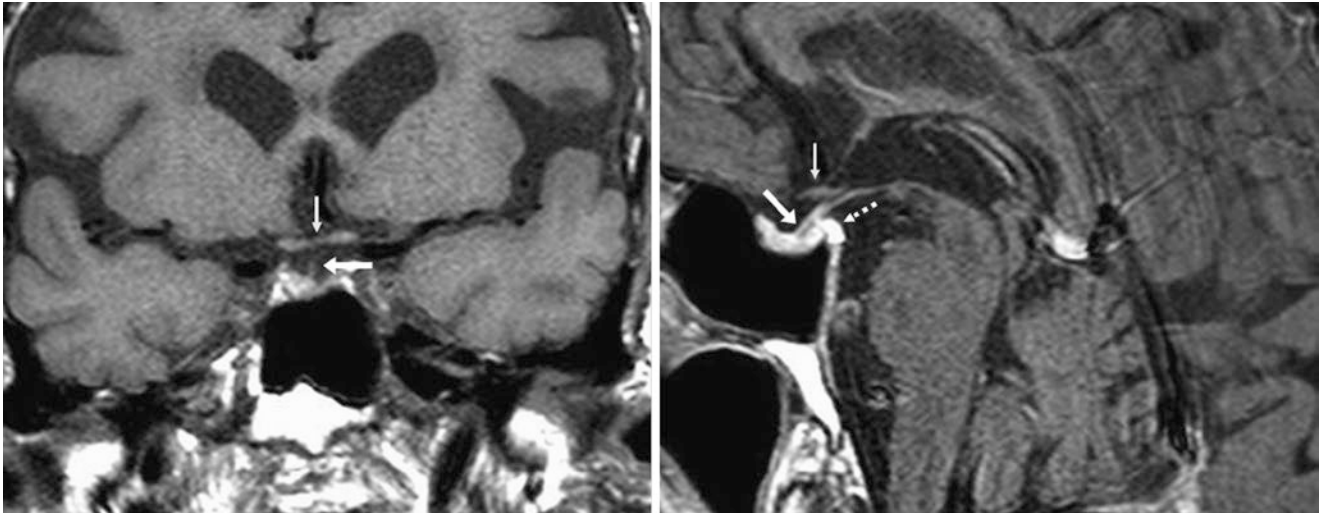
The patient was a 78-year-old male with visual symptoms of unknown etiology. A 1.5 T MRI found normal mild asymmetry; the right lobe was slightly more prominent, along with infundibular shift to the right (*arrows*) on coronal T1WI (*left*). There was no history of prior
